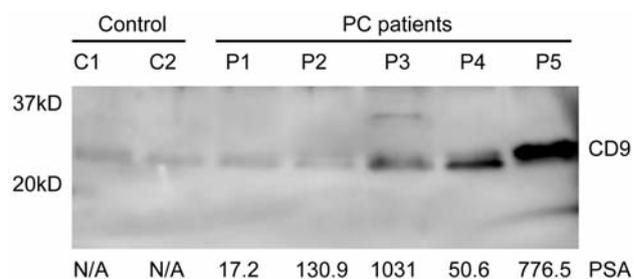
Analysis of prostate cancer-related exosomes isolated from the plasma. Exosomes isolated with anti-PSMA beads from the plasma of healthy volunteers (C1 and 2), prostate cancer patients without metastasis (P1 and P2), patients with advanced prostate cancer (P3) and those with castration- and chemotherapy-resistant prostate cancer (P4 and P5) were subjected to western blotting with an anti-CD9 antibody.
